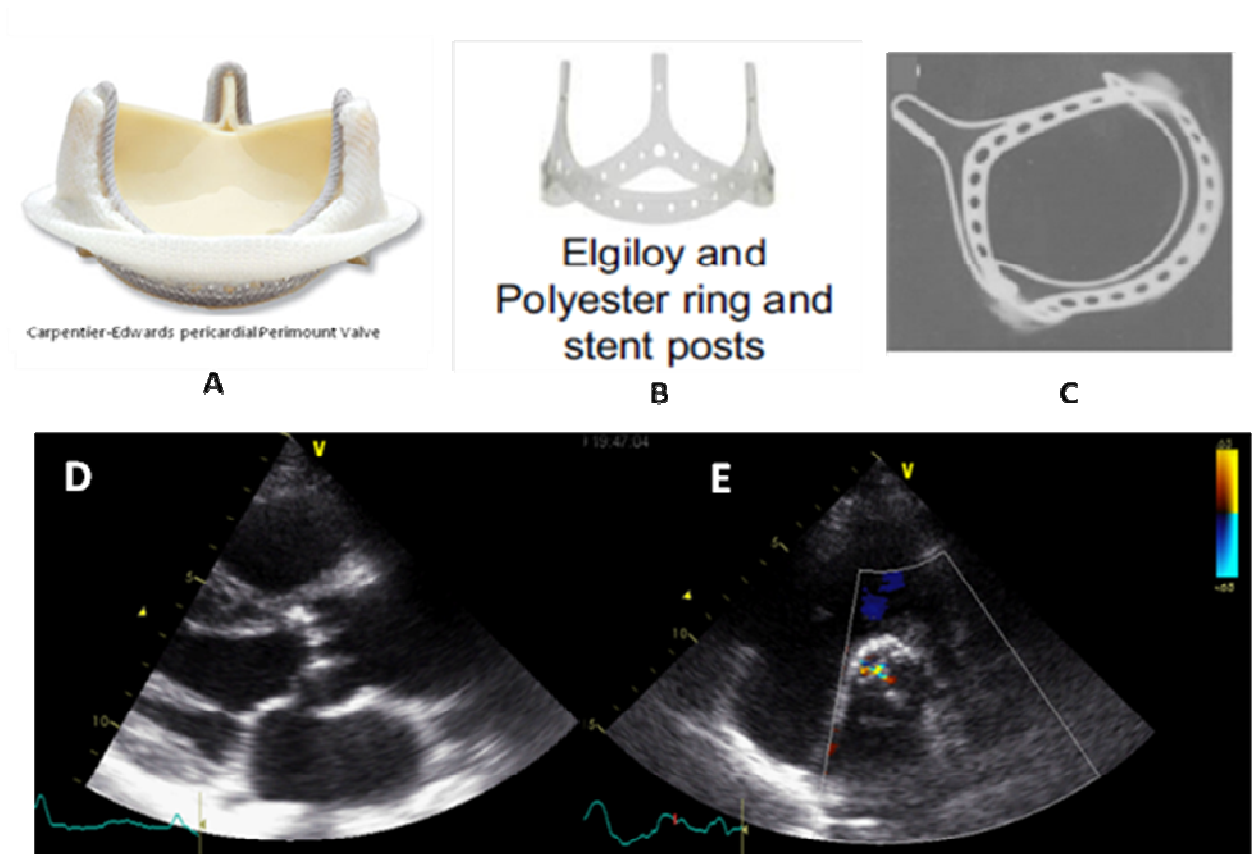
case n°1 (A) pericardial bioprosthesis; (B) complete metallic stent; (C) stent radiology; (D) preoperative bidimensional echocardiography; (E) preoperative color Doppler echocardiography.
